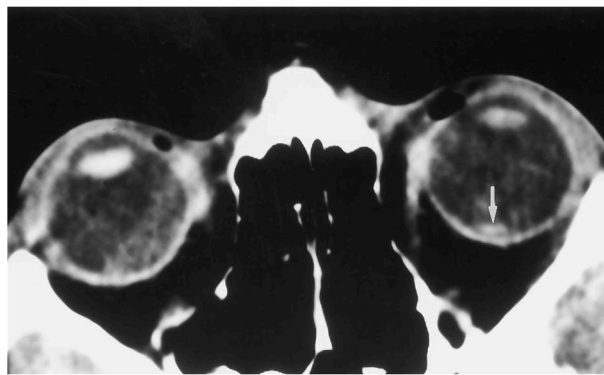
Case 2: 29-year-old woman 12 days postpartum suffered rupture of a giant fusiform left middle cerebral artery aneurysm. A visual field deficit was noted 3 weeks later, at which time fundoscopy revealed central retinal and vitreous hemorrhage in the left eye. A CT scan obtained on the day after the intracranial hemorrhage revealed a hyperdense nodule (*arrow*) on the central left retinal surface corresponding to the fundoscopic abnormality.
